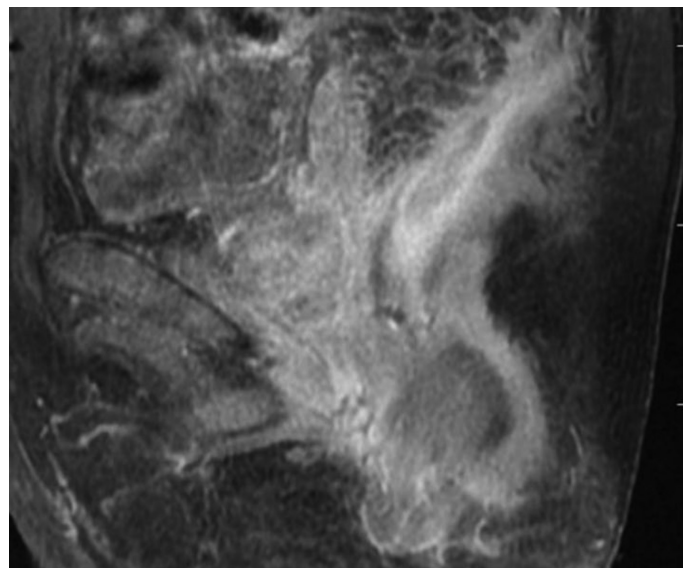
Early postoperative sagittal magnetic resonance imaging shows counter clock-wise manner transposed gracilis muscle around the surgical anal canal, and anorectal angle reconstruction
